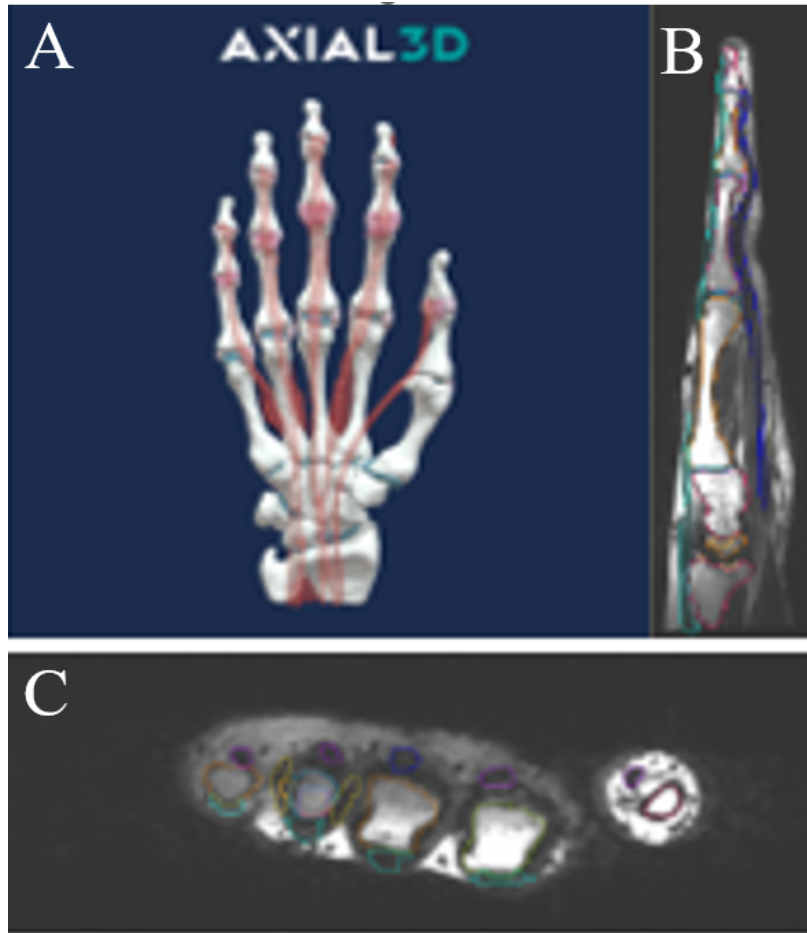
Axial3D uses image segmentation to produce digital 3D model of bones, ligaments and tendons. Figure 2.4A is a digital 3D hand model in a supine orientation presented in the top left. Segmentation process done by Axial3D with provided MRI with figure 2.4B being the sagittal view of the process and Figure 2.4C being the axial view.
